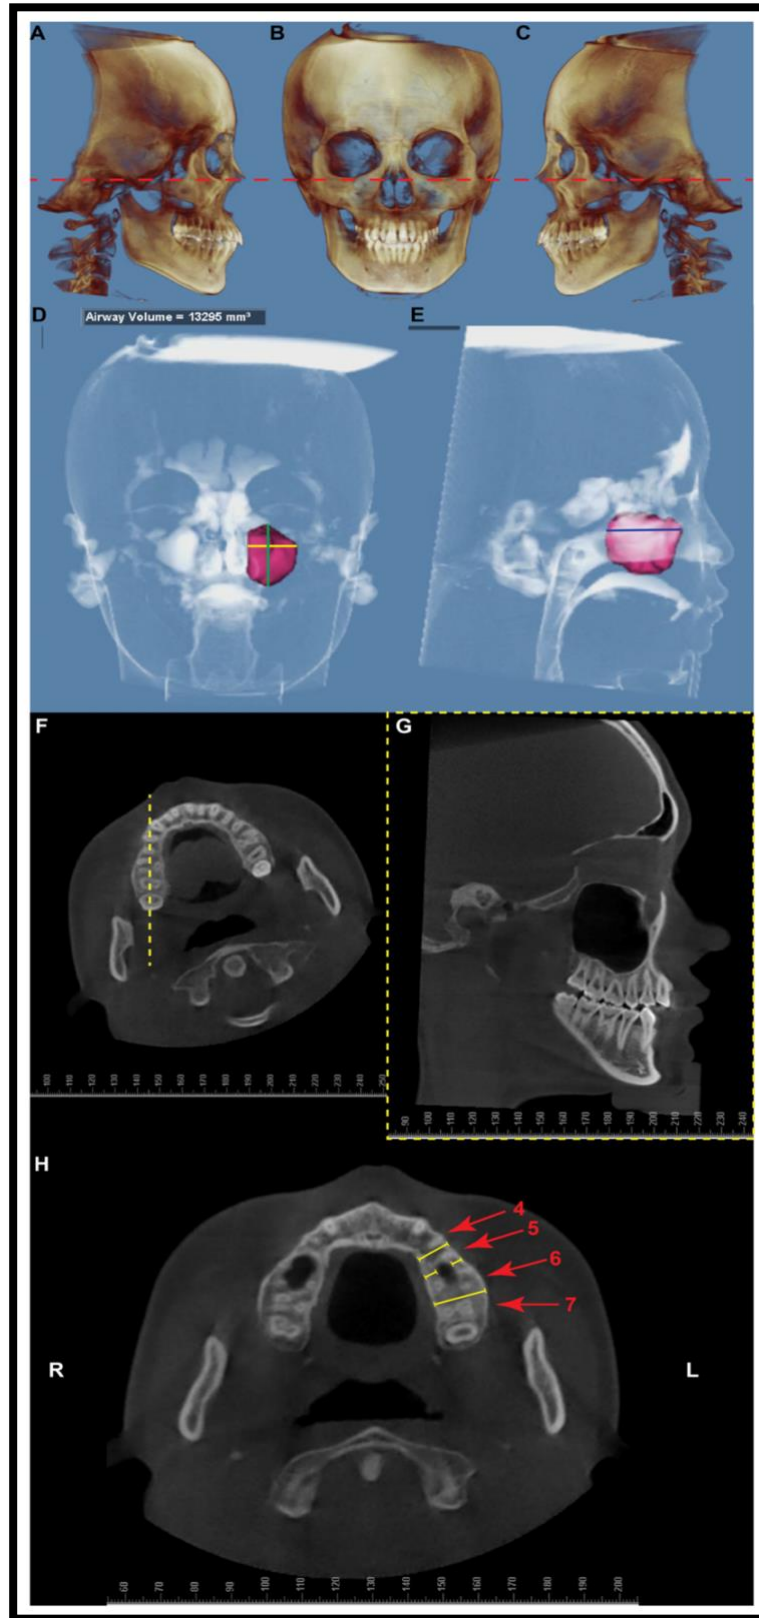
The CBCT image was oriented to Frankfort horizontal plane (red dash line) using
